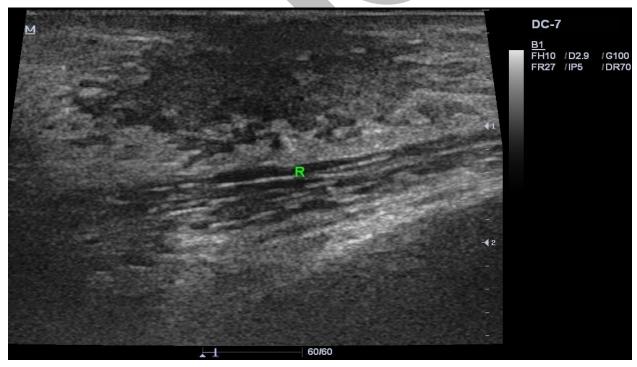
Ultra Sonography of breast (right side) suggestive of Gynaecomastia
